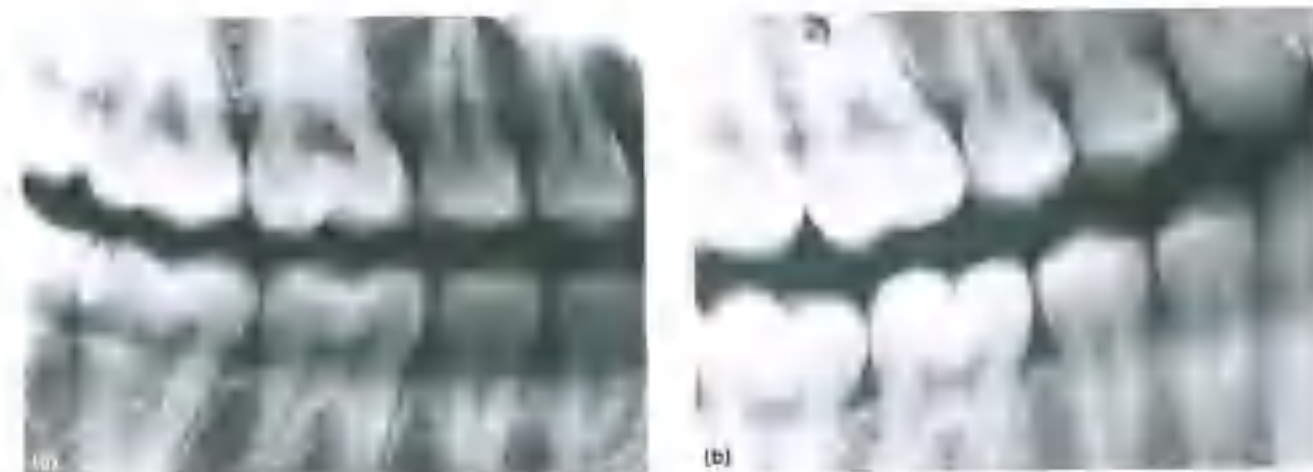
(a) A 25-year-old presenting with toothache in the lower right first molar (46). The bitewing radiograph reveals a deep occlusal dentin lesion (146). (b) Bitewing radiograph taken less than 2 years previously. It is far too light, without contrast, and useless for caries diagnosis.
